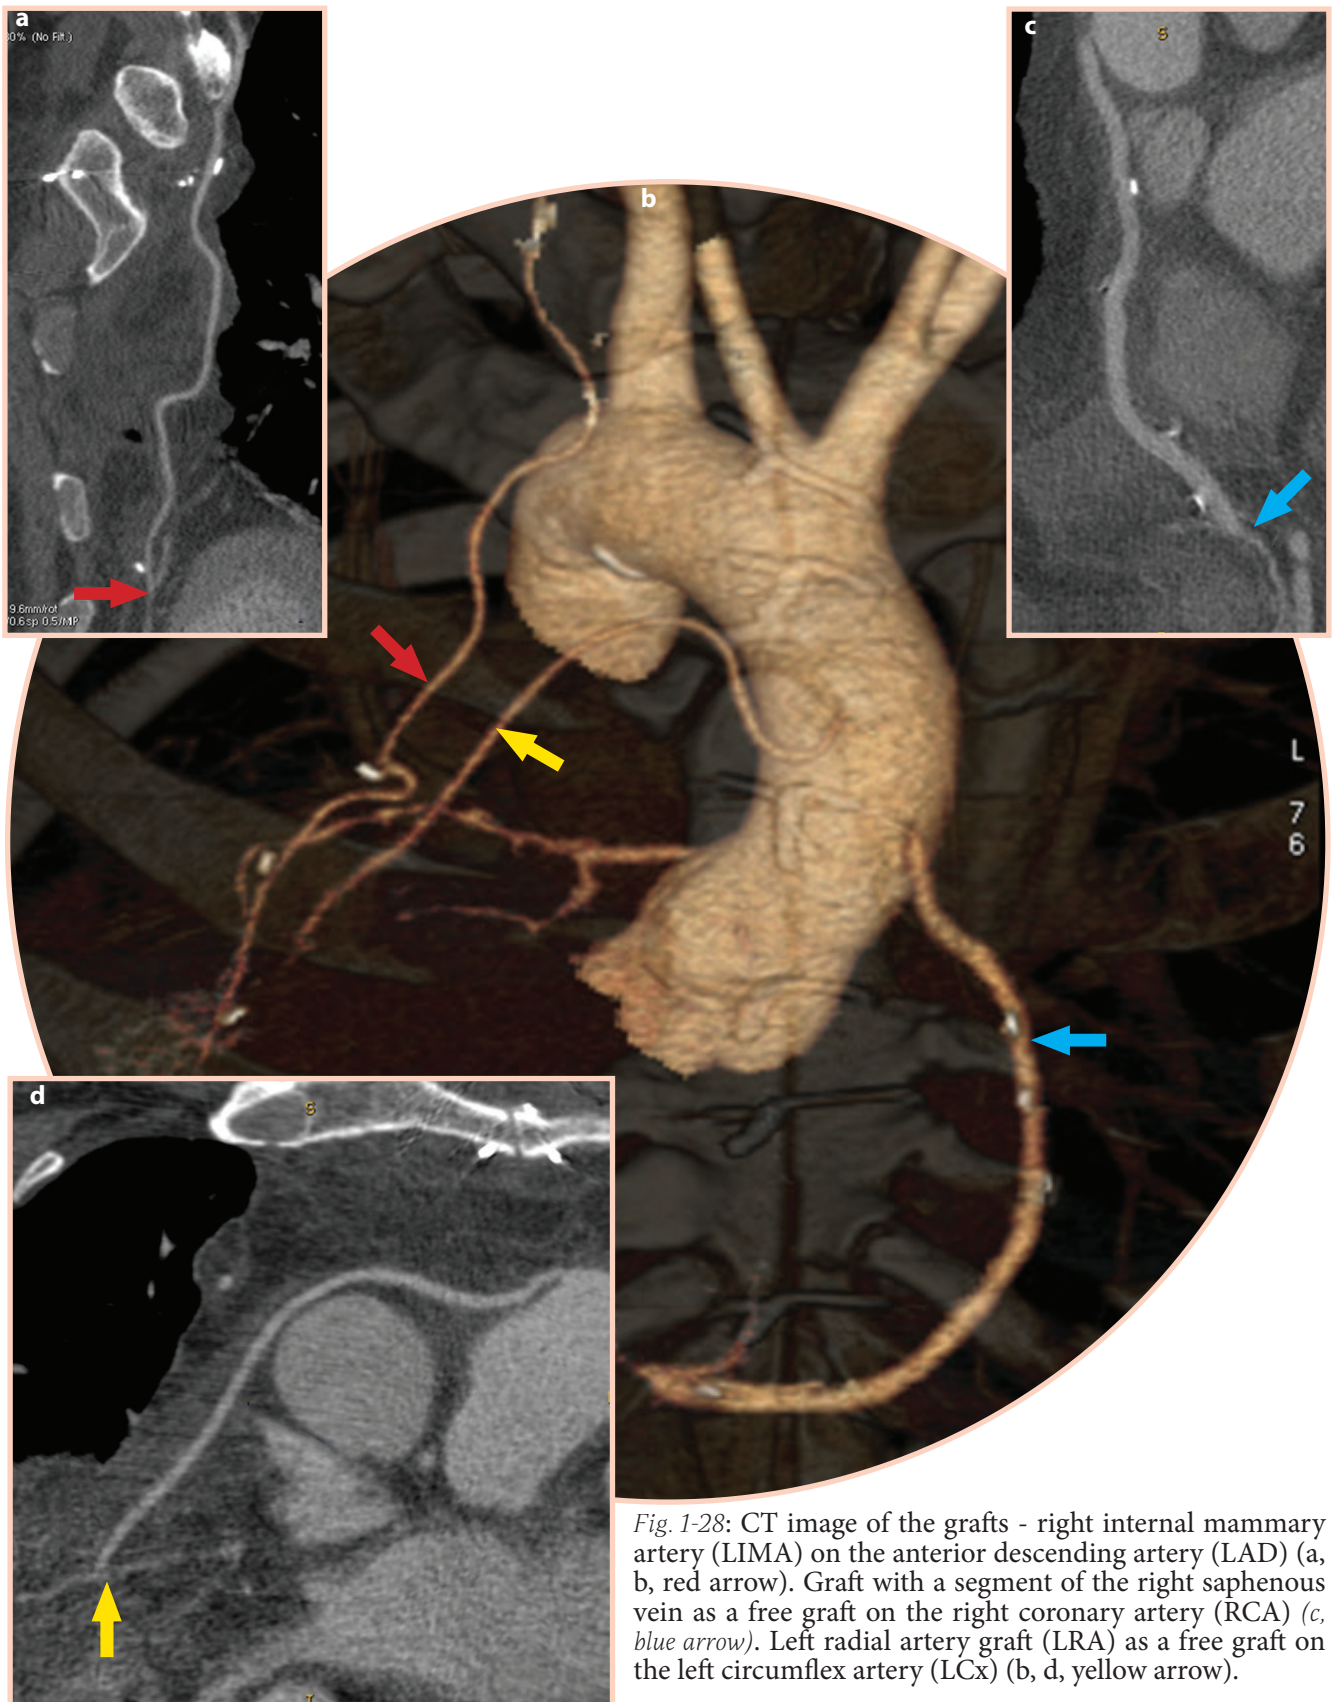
CT image of the grafts - right internal mammary artery (LIMA) on the anterior descending artery (LAD) (a, b, red arrow). Graft with a segment of the right saphenous vein as a free graft on the right coronary artery (RCA) (c, blue arrow). Left radial artery graft (LRA) as a free graft on the left circumflex artery (LCx) (b, d, yellow arrow).
